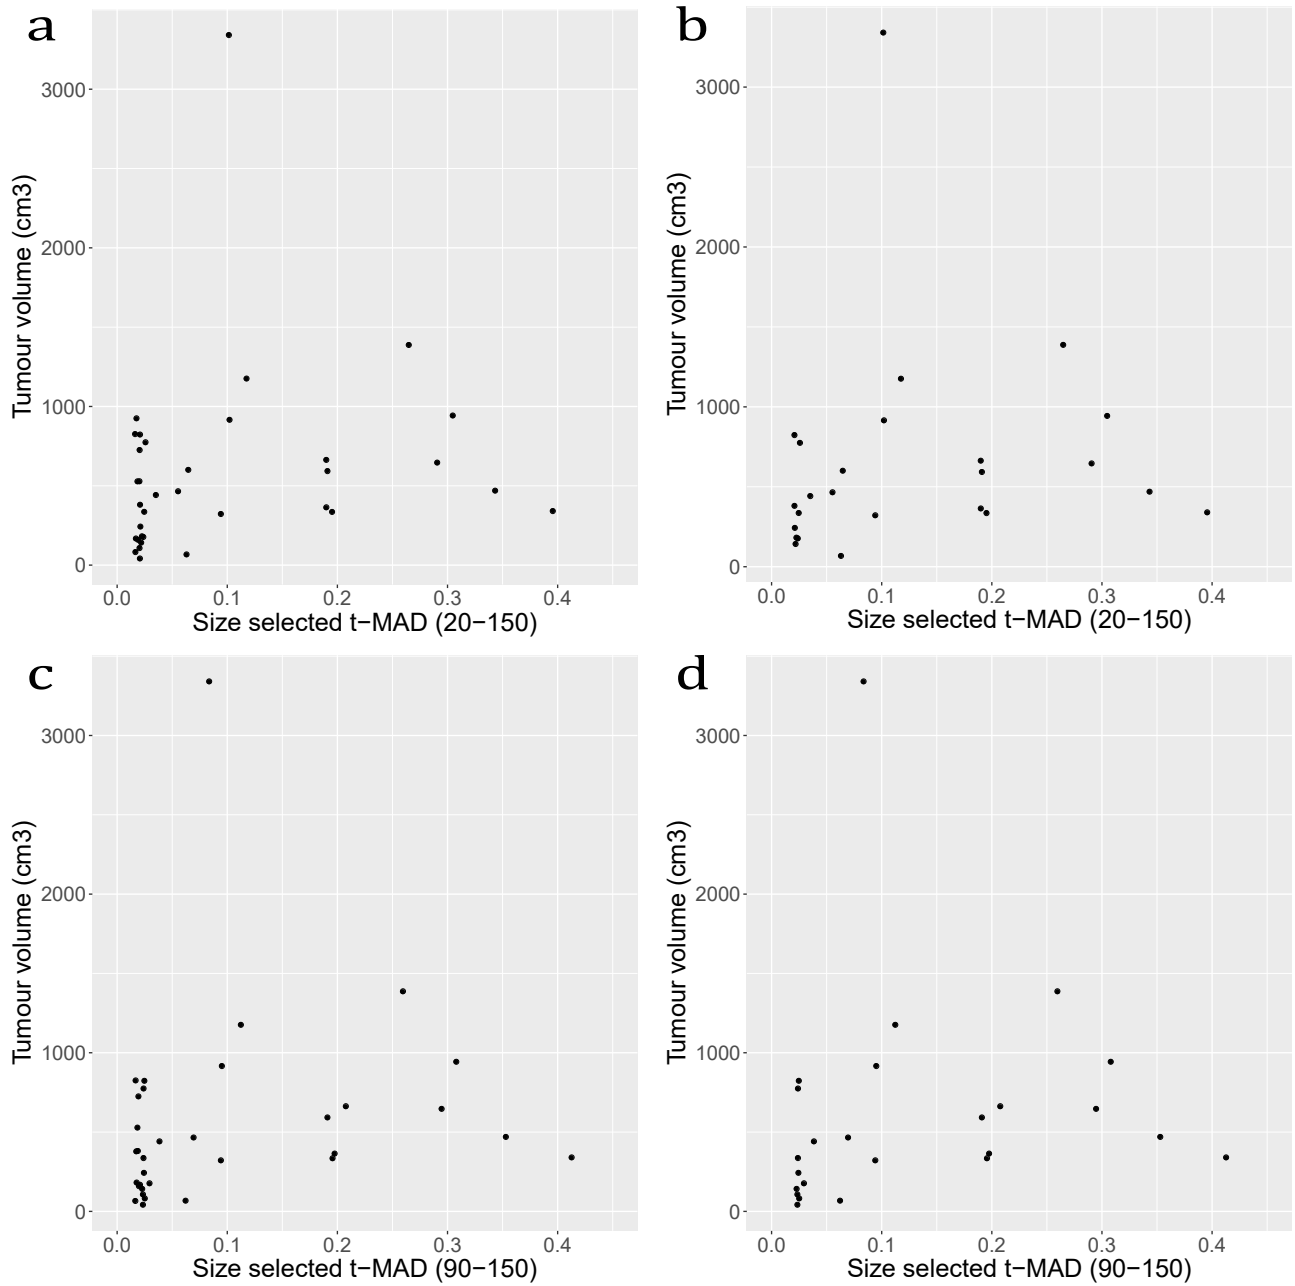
Comparison of size selected t-MAD score for detected cases with total tumour volume measured by 3-D CT reconstruction. a) 20–150 bp, cut off upper limit healthy controls. b) 20–150 bp, cut off upper limit benign controls. c) 90–150 bp, cut off upper limit healthy controls. d) 90–150 bp, cut off upper limit benign controls.
